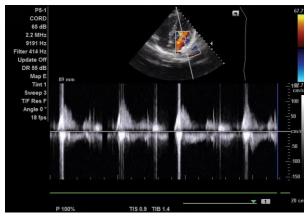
2D TTE, Apical 4 chamber view; Doppler modeshows Mitral regurgitation
